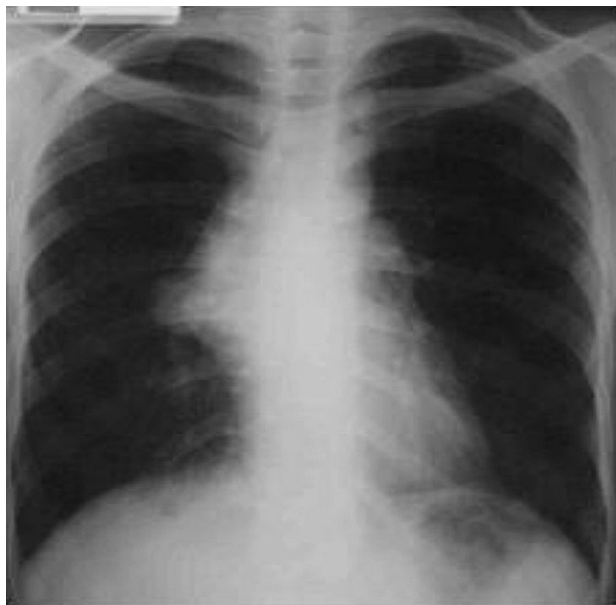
Chest radiography: anterior mediastinal mass, eccentric to the right.
